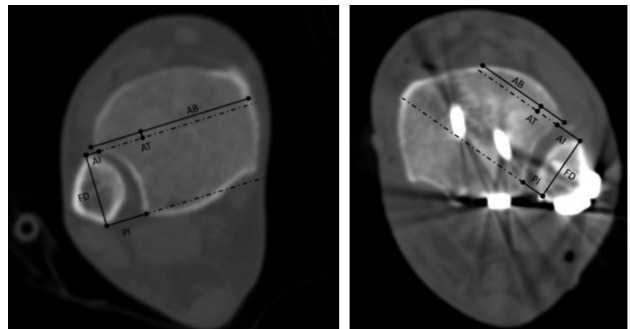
Syndesmotic malreduction assessment on axial CT utilizing a novel method.
